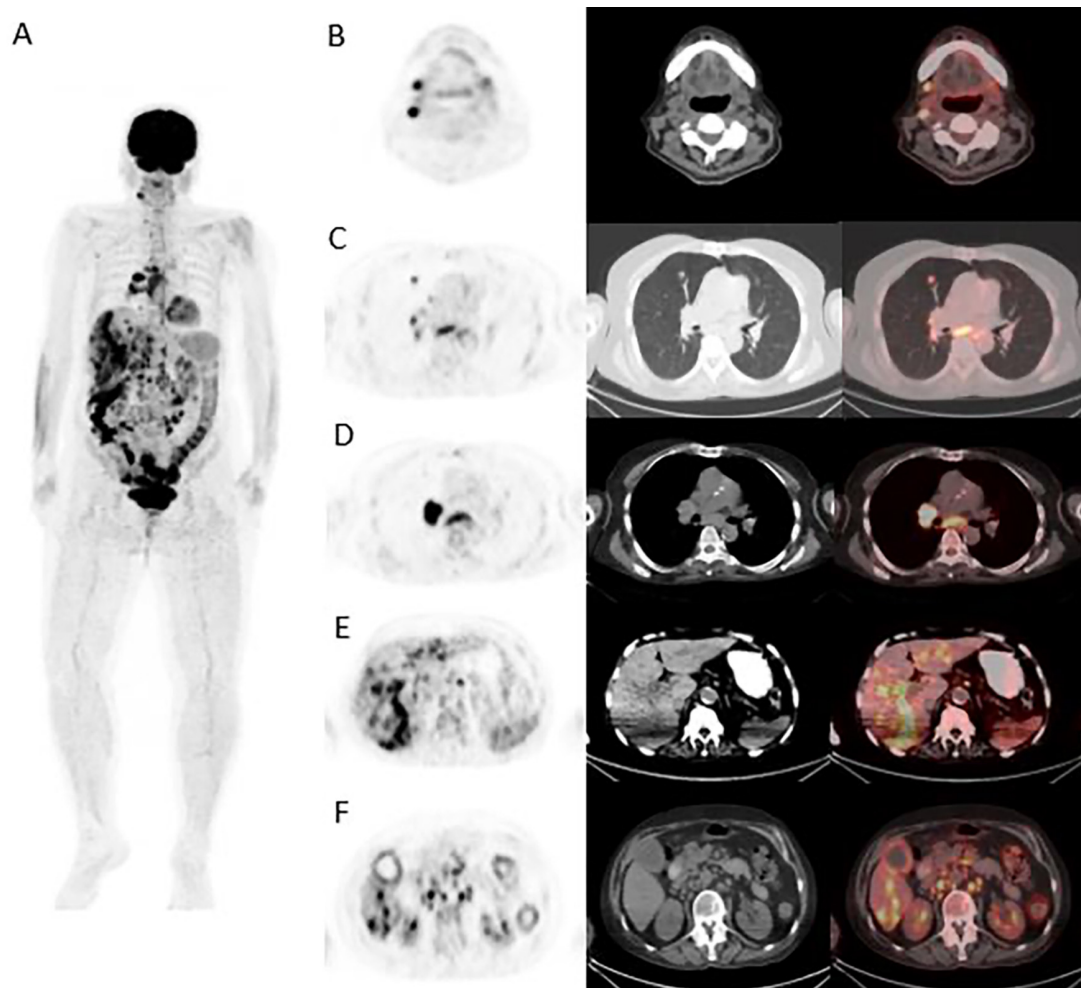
A 62-year-old female patient presenting with newly onset fatigue, weakness, night sweats, and weight loss underwent an ^{18}F -fluorodeoxyglucose positron emission tomography/computed tomography (PET/CT) scan for malignancy screening. Maximum intensity projection image (A), together with transaxial PET, CT, and PET/CT fusion images, demonstrated multiple intensely hypermetabolic lymph nodes in supra- and infradiaphragmatic lymphatic stations (B, D, F); hypermetabolic nodular lesions in the parenchyma of both lungs (C); hypermetabolic hypodense lesions in both lobes of the liver (E); and diffuse hypermetabolism in the spleen and segments of the colon (E, F). Excisional biopsy of a cervical lymph node demonstrated tuberculous lymphadenitis, while colonoscopy revealed a granulomatous appearance consistent with tuberculosis. Biopsy of the hypermetabolic liver lesions showed no evidence of malignancy.
